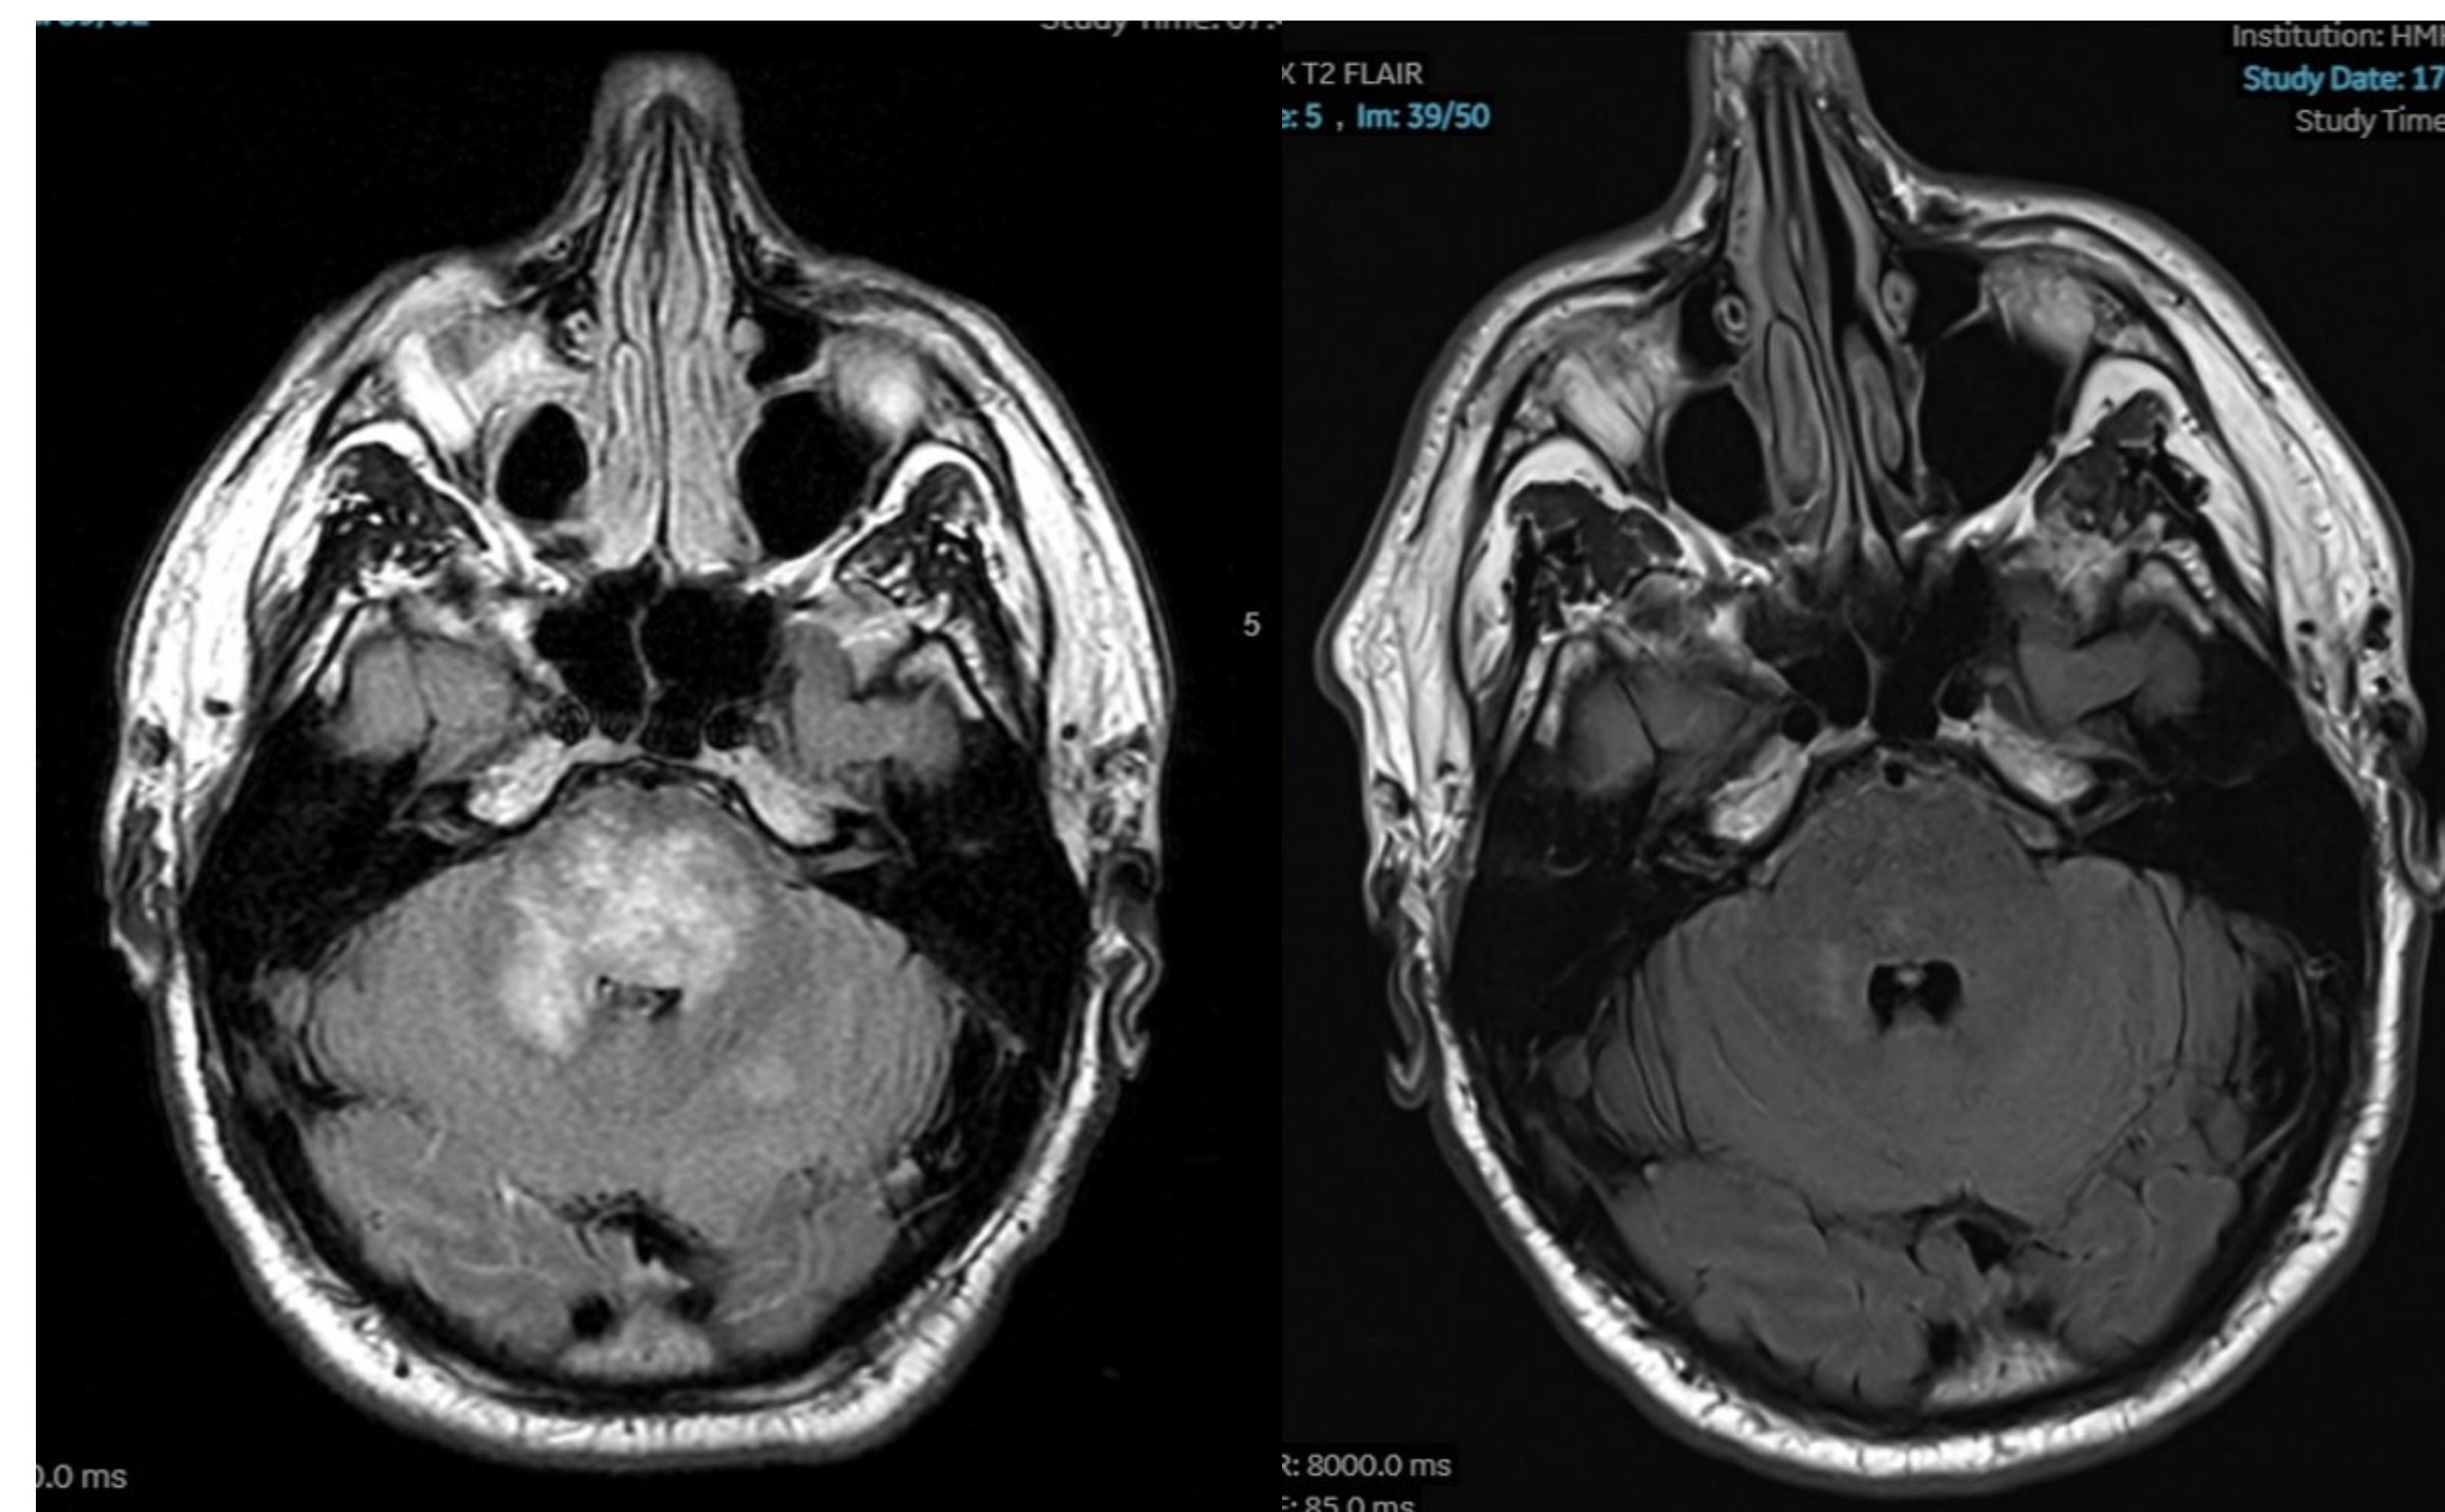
Axial T2 FLAIR MRI demonstrating posterior fossa lesion pre-treatment (left) and post-treatment (right)
